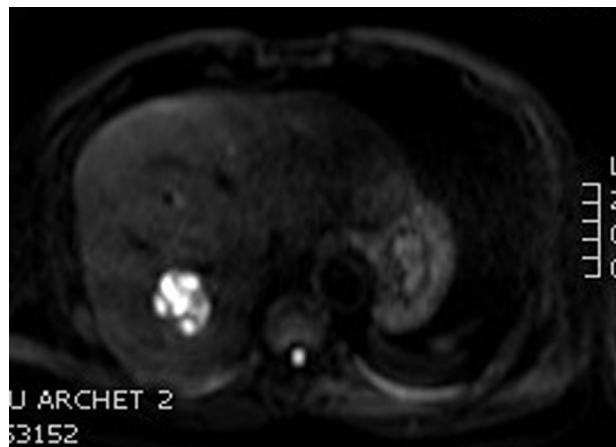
MRI showing a liver abscess measuring 32 × 37 mm.
